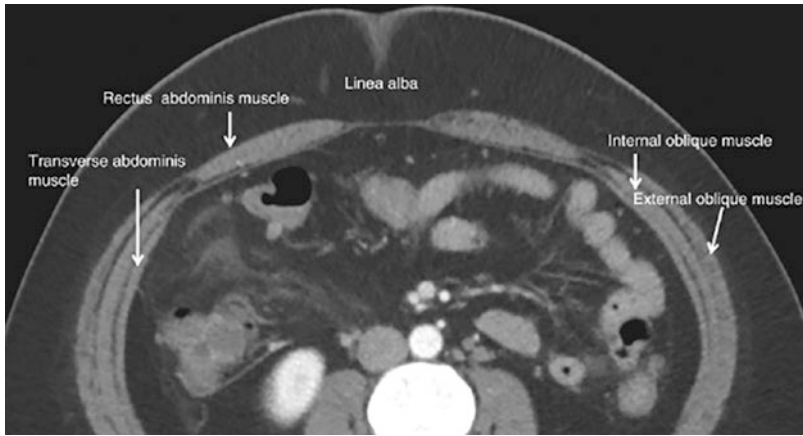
Axial CT demonstrating the anatomy of abdominal wall
